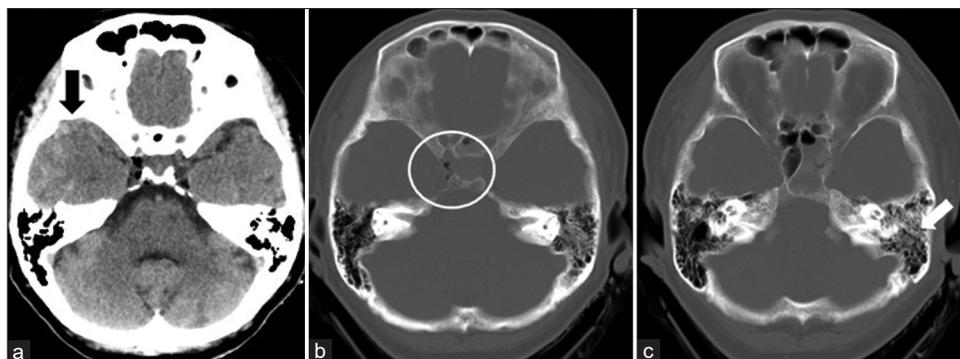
(a-c) Head computed tomography reveals a cerebral contusion in the right temporal lobe (black arrow), right pneumoencephalopathy (circle), and a left petrous bone fracture (white arrow).
